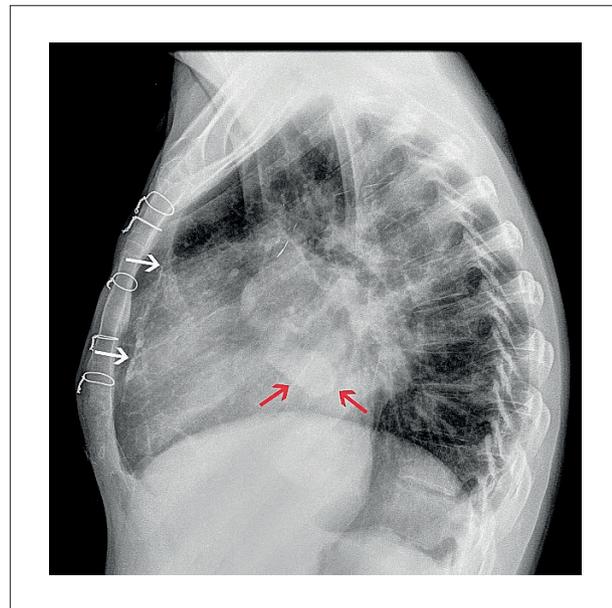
Chest radiography – lateral view. The hyperdense heart lesion (red arrows) and the calcified pleural line (white arrows) are visible.
